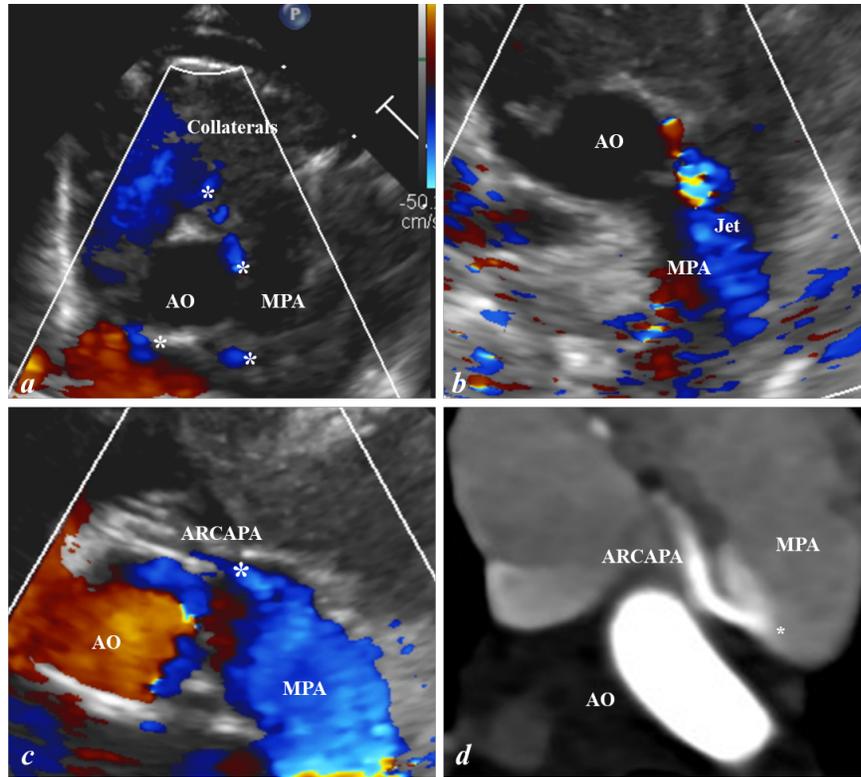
a. A network of small multiple coronary vessels (*) around aorta (AO), being the small initial collaterals between the left and right coronary artery; b. a systo-diastolic jet of flow into the MPA which represents the left-to-right shunt through the abnormal coronary vessel; c. the origin (*) of the RCA from the MPA (ARCAPA) with retrograde inverted «blue» flow inside, running anterior to the aorta. d. CT-scan image showing RCA arising (*) from MPA.
